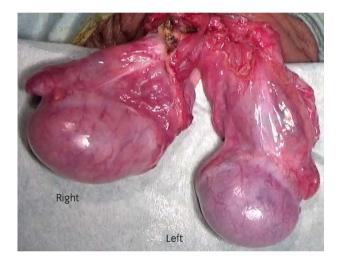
The testes on both sides were exposed. The left testis was slightly pale and blood flow was confirmed using color Doppler ultrasound.
